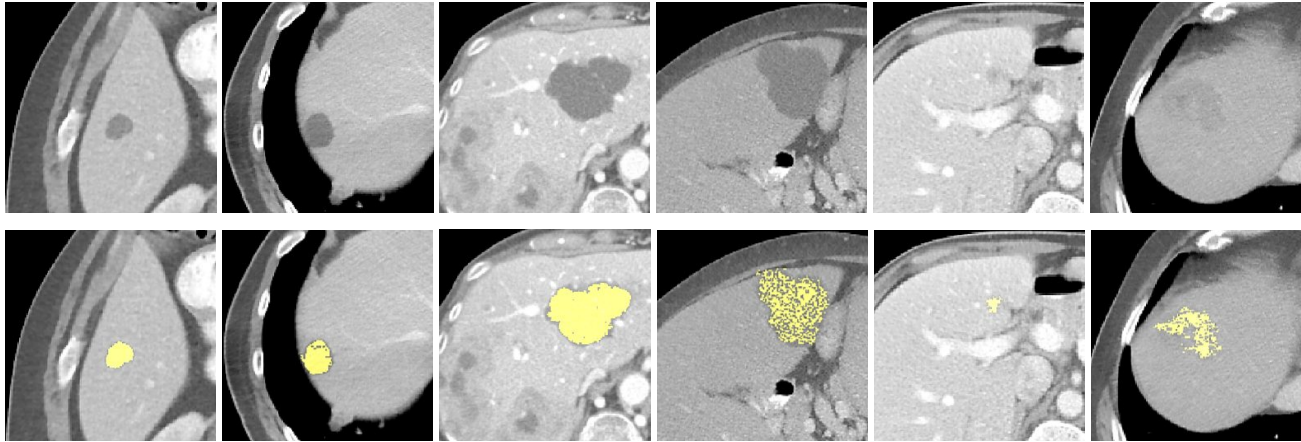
Examples of lesion delineations where the result is overlaid on the original CT slice for six lesions. Columns: 1, 2, 3, 4 – focal cysts, peripheral in columns 1, 2, and 4 and central in 3. Columns 5, 6 – focal, peripheral, heterogeneous, and malignant lesions.
